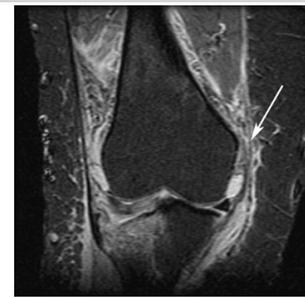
MCL disruption on a coronal MRI in a patient with a Schatzker II fracture pattern
